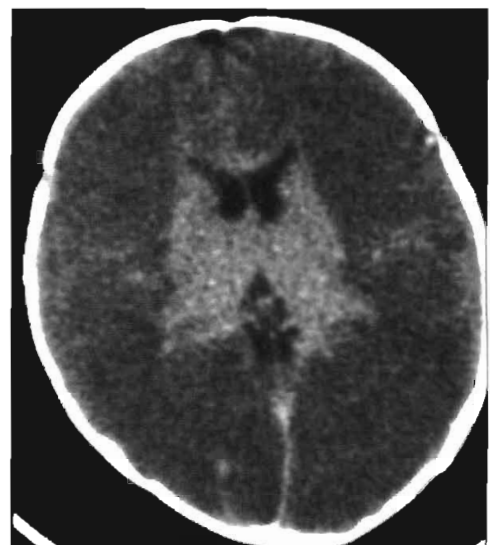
Global anoxia. Axial CT scan of a child following cardiac arrest. There is diffuse low density in the cerebral hemispheres and compression of the ventricles and sulci, reflecting the increased water accumulation (edema) and resultant mass effect. The basal ganglia and thalami appear bright, showing the "reversal" sign of global anoxia.
